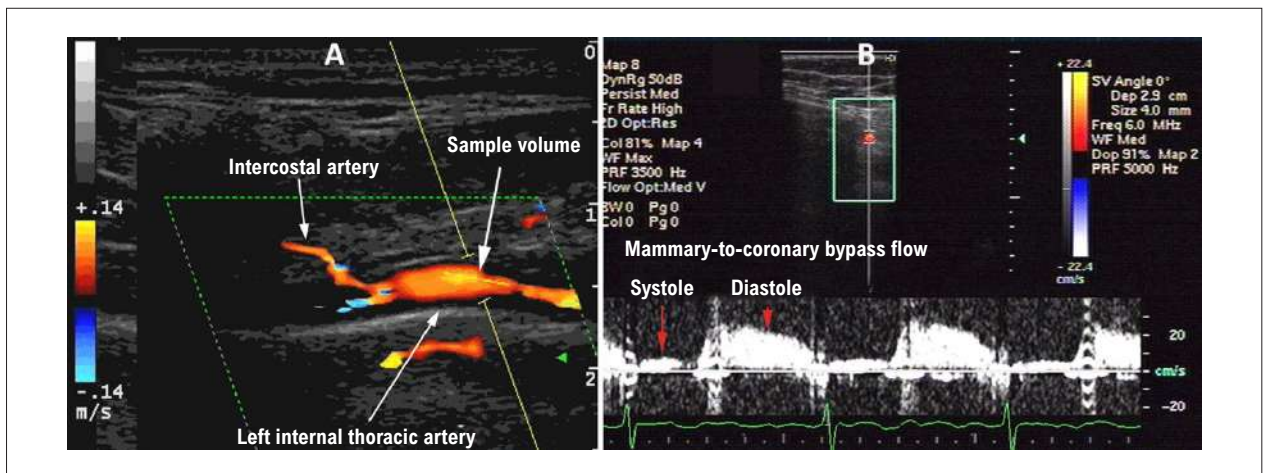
A: Detection of internal thoracic artery flow with pulsed Doppler sample volume placement. B: Recording of flow in the internal mammary-to-coronary artery graft, showing biphasic flow with diastolic predominance, indicating that the graft is patent.
